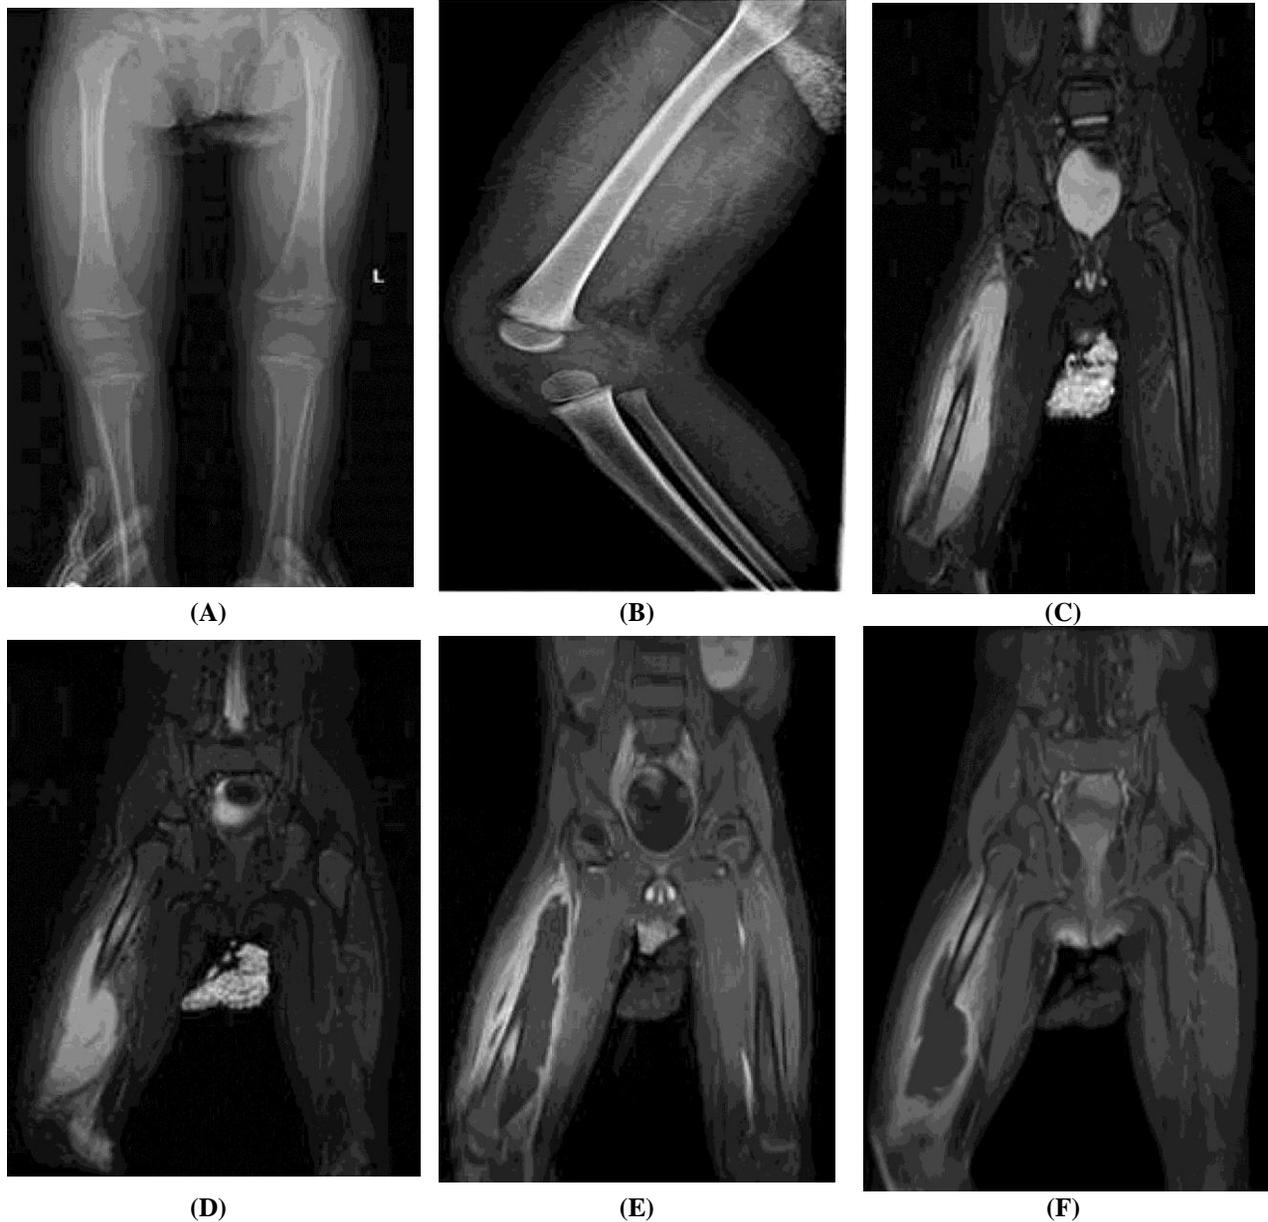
A known case of *Right femur osteomyelitis* for 4 years old boy with sickle cell disease complaining of painful swelling right thigh tenderness and fever. (A&B) Radiography of right femur AP and lateral views show normal bone with soft tissue swelling. MRI (C&D) Coronal STAIR demonstrate diffuse abnormal heterogeneous medullary signal intensity at the right femoral diaphysis display high signal at STAIR, no evidence of cortical destruction. (E&F) T1WI fat suppression without and with IV contrast respectively showing abnormal heterogeneous medullary cavity enhancement. Large circumferential juxta-cortical fluid intensity about 15cm x5cmx5cm with thick irregular peripheral enhancement.
